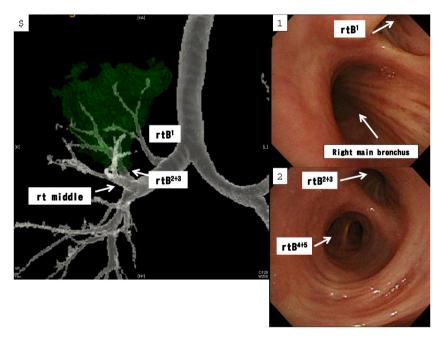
Bronchial running as seen on 3D-CT (A). The bronchial running as demonstrated by bronchoscopy (B, C).
